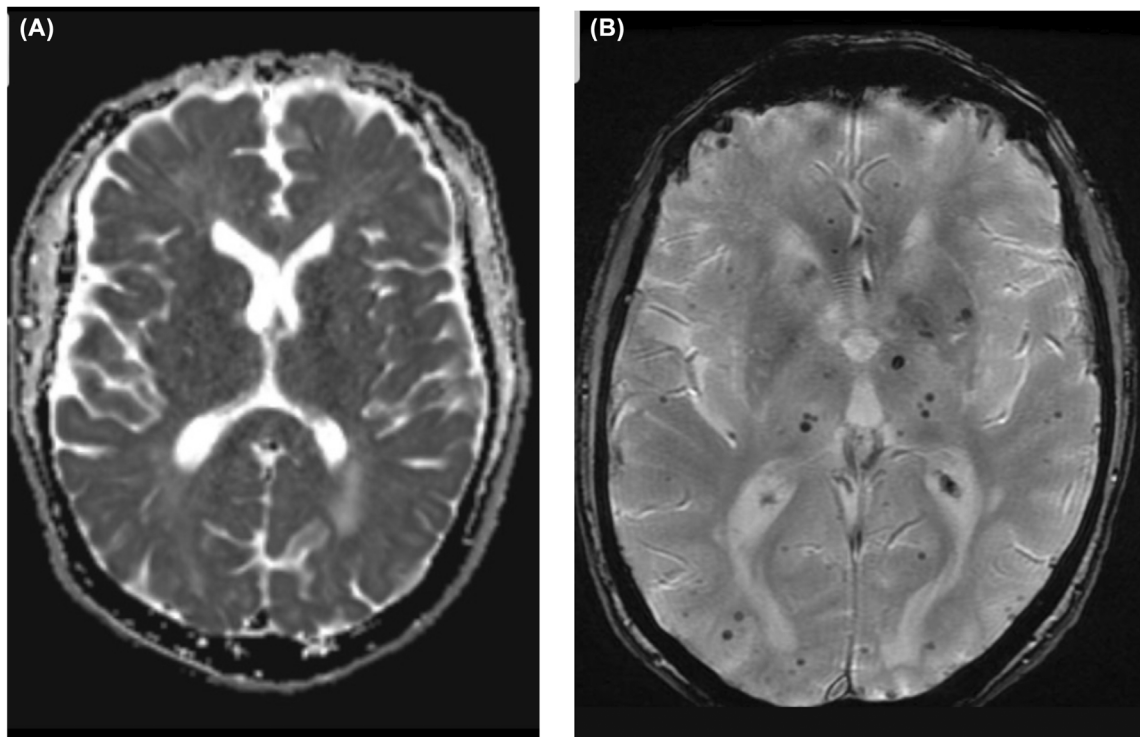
(A) CAA MRI ADC axial (B) CAA MRI GRE axial.
